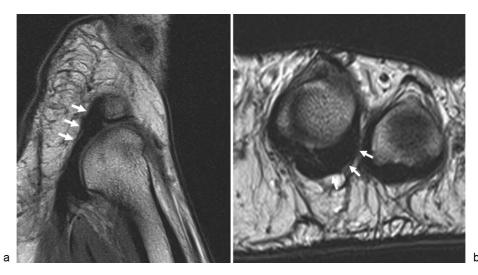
Normal lateral plantar plate. (a) Sagittal proton-density and (b) short-axis T2 MR images demonstrating a normal lateral plantar plate of the second MTP joint (white arrows).
